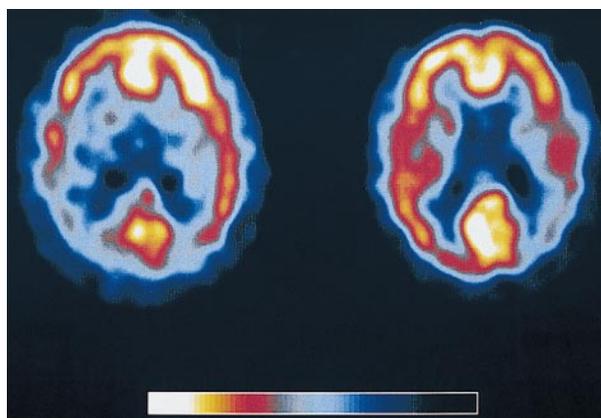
Cerebral transaxial images 70 mm above the canthomeatal plane obtained using technetium Tc 99m hexamethylpropyleneamine oxime and single-photon emission computed tomography (SPECT) for 2 subjects (apolipoprotein E genotype, 3,3) demonstrating significant parietal rCBF asymmetry. The patients' left sides appear on the right in these images. Left, A 60-year-old left-handed woman who evidenced profound visuospatial deficits with relatively preserved language abilities, including a neuropsychological asymmetry index (NAI) of 28 (language performance higher than visuospatial construction) derived from the cognitive subscale of the Alzheimer's Disease Assessment Scale. The SPECT reveals relative right parietal rCBF reduction (AI = 19.6%). Right, A 76-year-old right-handed woman who demonstrated disproportionate language deficits, including an NAI of 23 (visuospatial construction performance higher than language). The SPECT reveals relative left parietal rCBF reduction (AI = 18.6%). Magnetic resonance imaging scans in both subjects revealed only diffuse cortical atrophy. In the entire sample of patients with Alzheimer disease, the NAI was modestly correlated with the parietal rCBF AI ($r = -.31$, $P = .025$; using the nonabsolute value of each index). All other abbreviations are explained in the legend to Figure 1.
